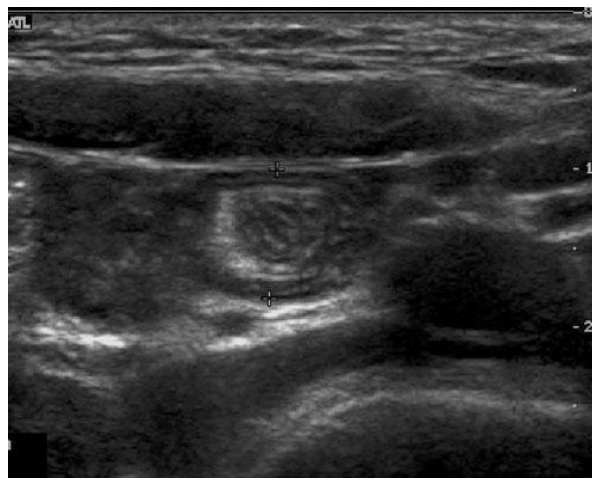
Ultrasonographic transverse plane image of a 7-year-old boy with abdominal pain and typical transient small bowel intussusception shows the crescent-in-doughnut sign (cursors). The diameter of the doughnut measured 0.84 cm and the thickness of the outer rim of the lesion measured 0.10 cm.
